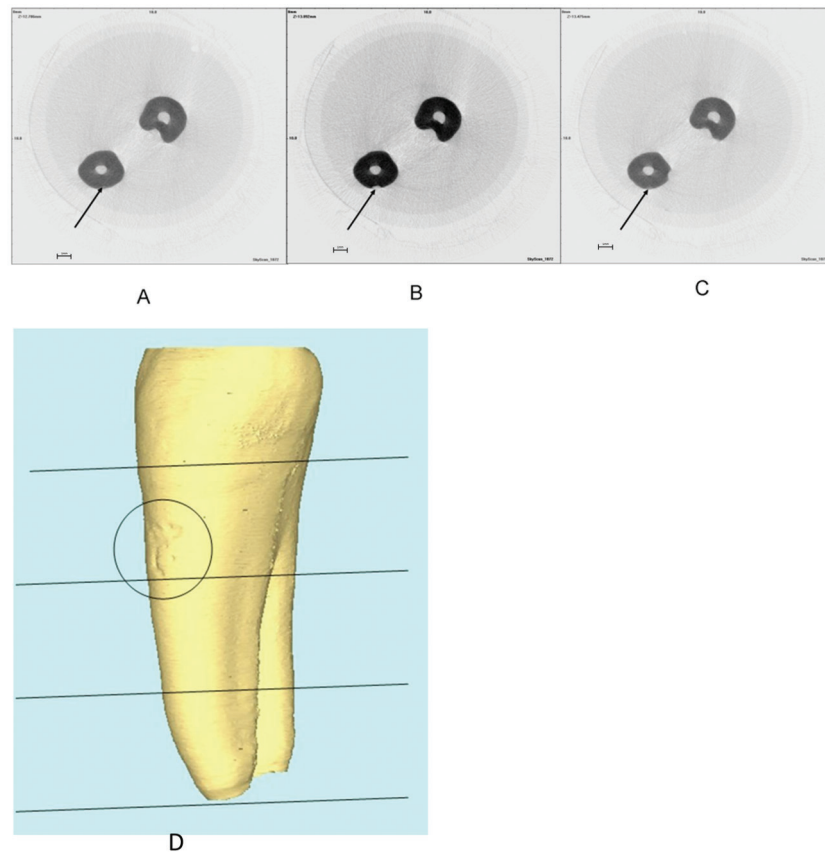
Cross-sectional and longitudinal views of microscans of the buccal root of a tooth that was exposed to continuous force. The cross sections visualize the beginning (A), middle part (B) and apical border (C) of a root resorption crater (arrows); D. At the micro CT scan the horizontal lines denote the division of the three root areas into cervical, middle and apical ones. The resorption crater (circle) is present on the cervical buccal surface
